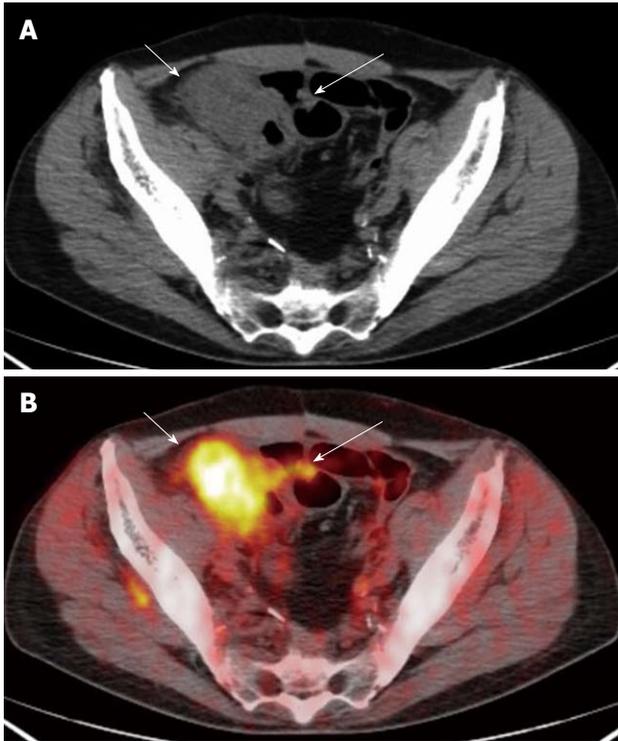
The computed tomography (A) and fused positron emission tomography/computed tomography (B) images show a neoplastic lesion of the caecum concentrating the radio-tracer (short arrows) (SUVmax 9.6). Focal radio-tracer uptake (SUVmax 3.6) of a contiguous ileal loop was disclosed on positron emission tomography/computed tomography (B) (long arrow) consistent with a short concentric wall thickening (A) (long arrow): the finding was suggestive of small bowel infiltration. The lesion was correctly classified as T4.
